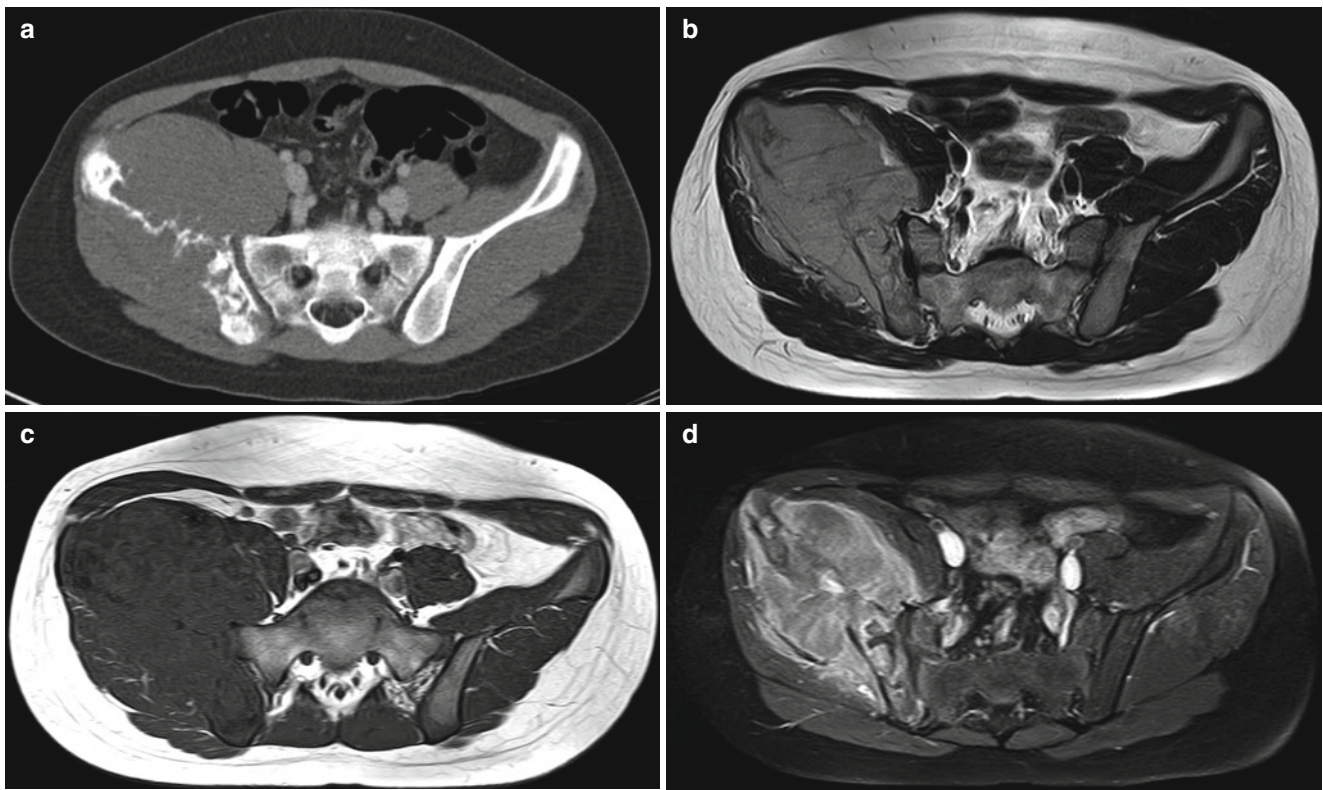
Primary lymphoma of ilium.* (a) CT shows a large soft tissue mass destroying the right ilium. (b–d) T2-weighted axial (b), T1-weighted axial (c), and postcontrast fat-suppressed axial (d) images
